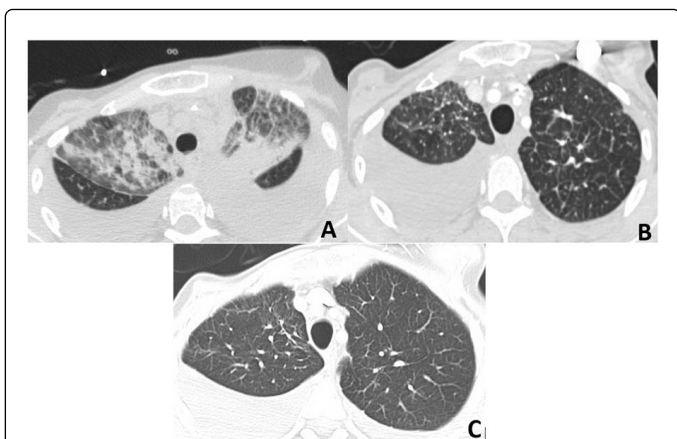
CT scan of the chest demonstrated clinical improvement of pulmonary lymphangitis from July 2012 to October 2013 after initiation of docetaxel, trastuzumab and pertuzumab.
